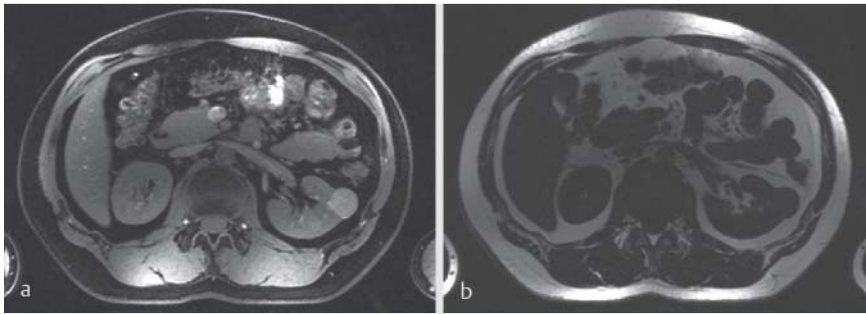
a shows a fat-saturated 2D FLASH image, b a concomitant water-saturated image of the abdomen, both acquired at 7 Tesla. Both images were acquired with TIAMO (Time-Interleaved Acquisition of Modes) showing excellent homogeneity of the imaged anatomy without B1 field inhomogeneities (Courtesy of Mr. St. Orzada Erwin L. Hahn Institute for Magnetic Resonance Imaging, University of Duisburg-Essen, Essen, Germany).
